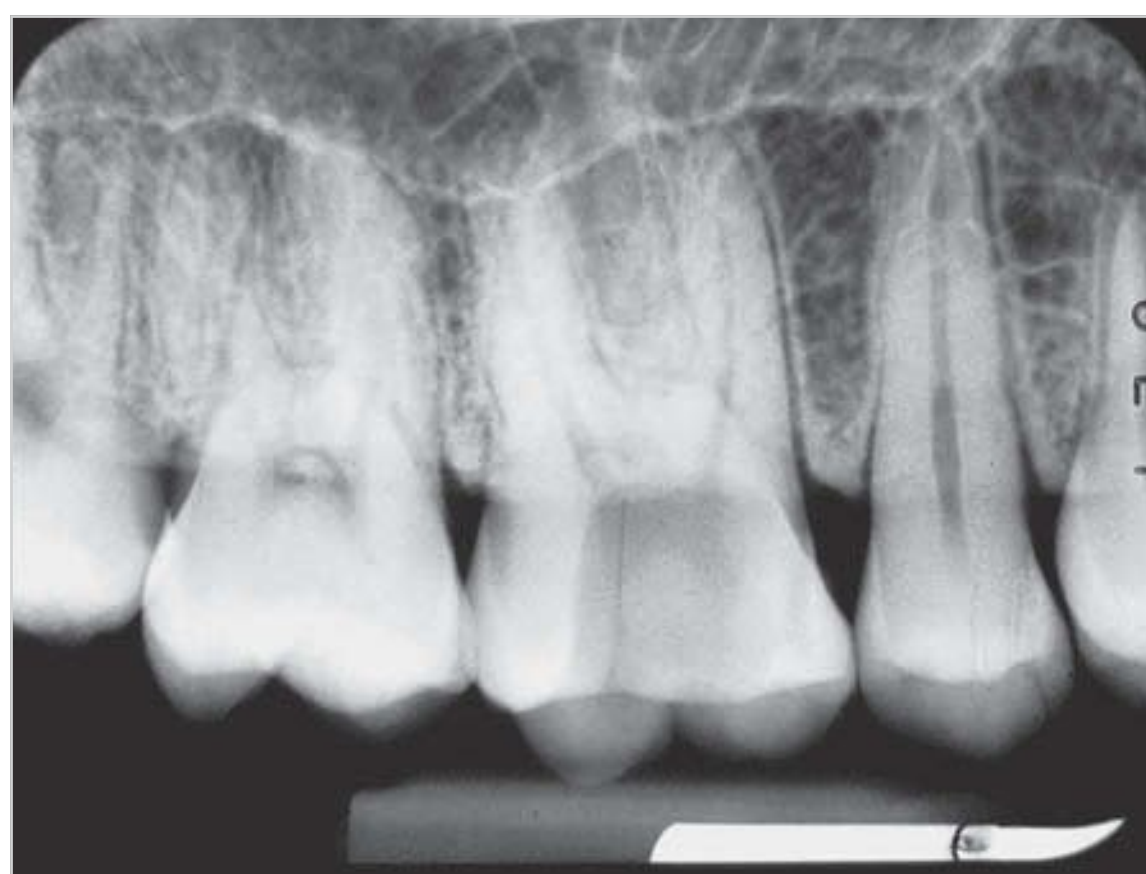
Paralleling technique: radiograph of the right maxillary teeth (same as in Fig. 9.30).
